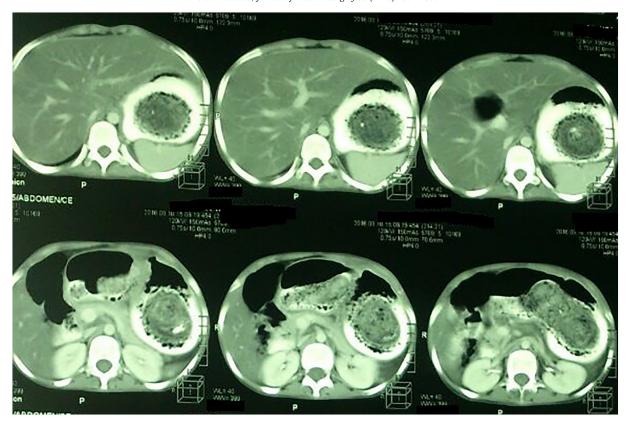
CT scan abdomen showing intragastric bezoar.
